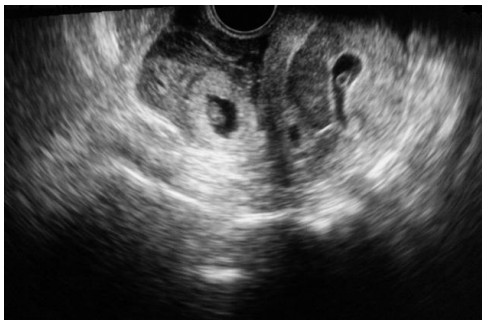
Shows heterotopic and uterine pregnancy on trans vaginal sonography
